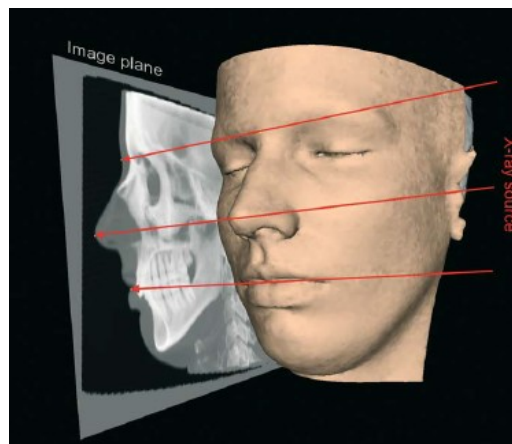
A virtual cephalogram is computed from the CT image volume (Gwen Swennen, 2006).
